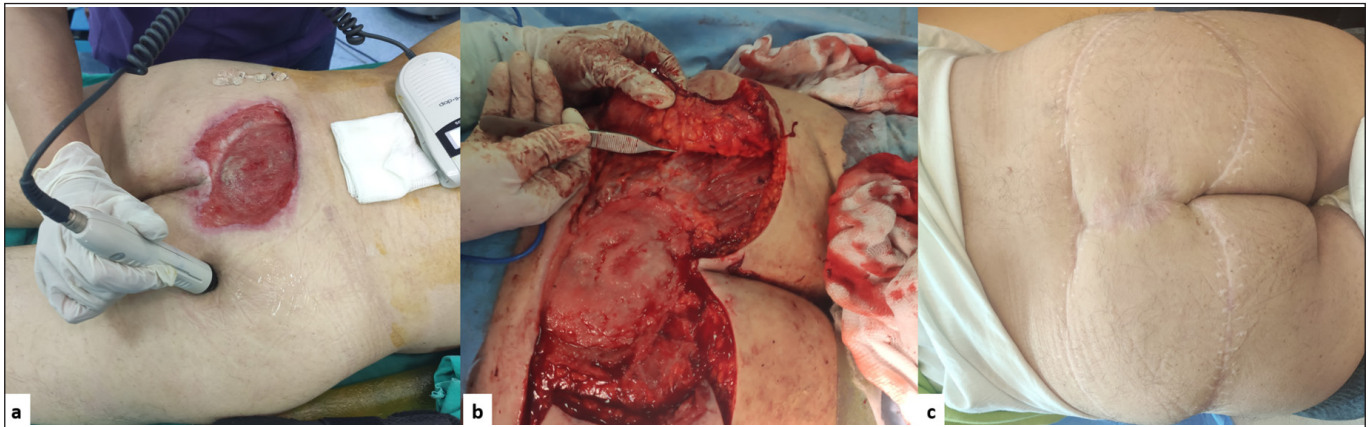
a. Sacral pressure sore , perforators are mapping with the handheld doppler b. Bilateral flaps were raised on a single perforator in each side, the perforator on the left side shown at the tip of the penset c. Postoperative 10 months
